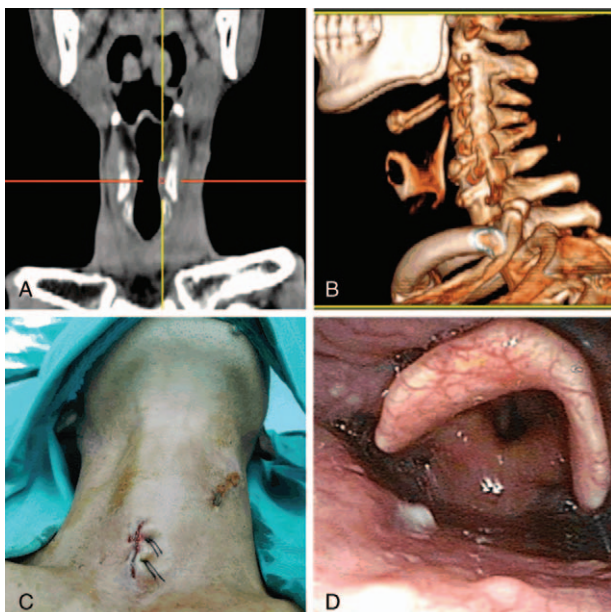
Postoperative images. (A) Postoperative CT showed the neck was unremarkable. (B) Three-dimensional reconstruction of the CT images showed the bone of neck was normal and that there was no foreign body residue remains. (C) The tracheotomy fistula was closed at postoperative day 16. (D) Electronic laryngoscope of pharyngeal cavity at postoperative day 20. CT = computed tomography.
